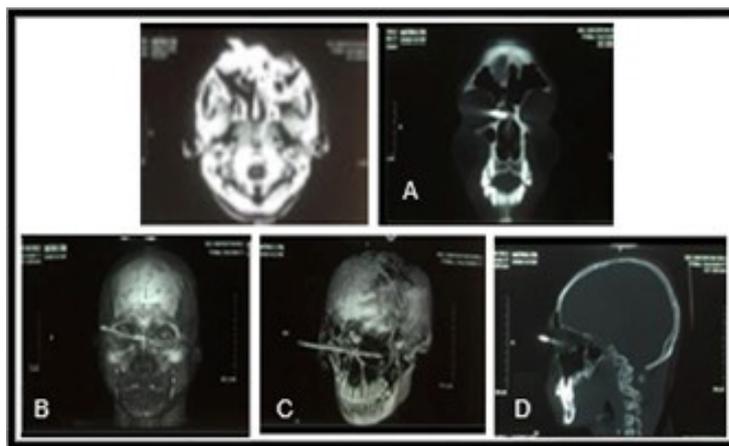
(A). The CT scan showed a metal density penetrating the ethmoid cell to the masseter muscles; (B, C) Hyperdense lesion at bilateral ethmoidal sinus and left maxillary sinus; (D) Fracture of the right ethmoid bone
